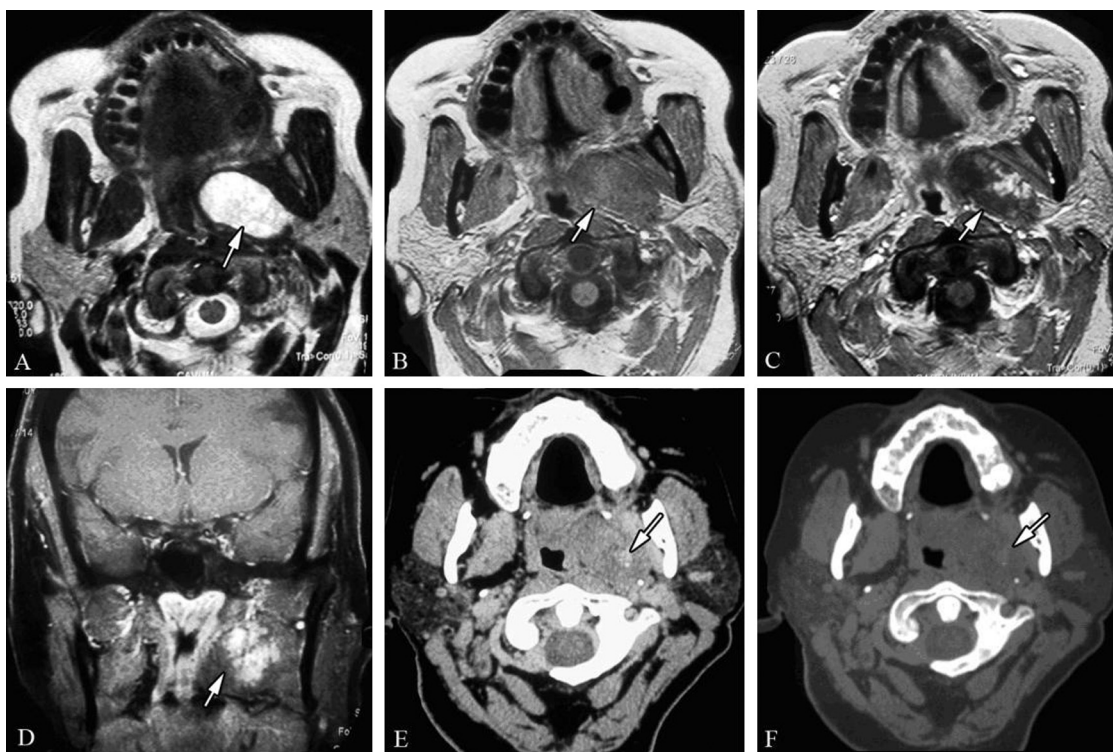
MRI scans: T2-weighted (A), axial T1-weighted (B), axial T1 with gadolinium (C), and coronal fat-saturated T1 with gadolinium (D); CT parenchymal window without injection (E) and bone window (F). A tissue lesion (A–F, arrows) is seen in the prestyloid parapharyngeal space located in the extended parotid space, displacing the lateral pterygoid muscle anteriorly and styloid diaphragm posteriorly. This formation produced a hyperintense T2 signal (A) and a hypointense T1 signal (B), with spotty enhancement (C, D). The formation was calcified on the CT scan (E, F).
